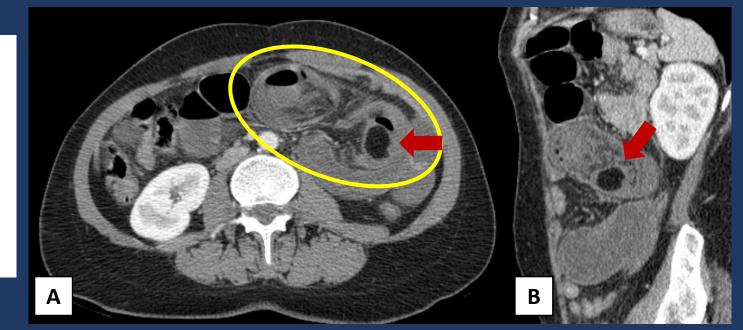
Axial (A) and coronal (B) contrast-enhanced CT demonstrates an ileal lipoma (arrow) acting as lead point for intussusception (circle).
